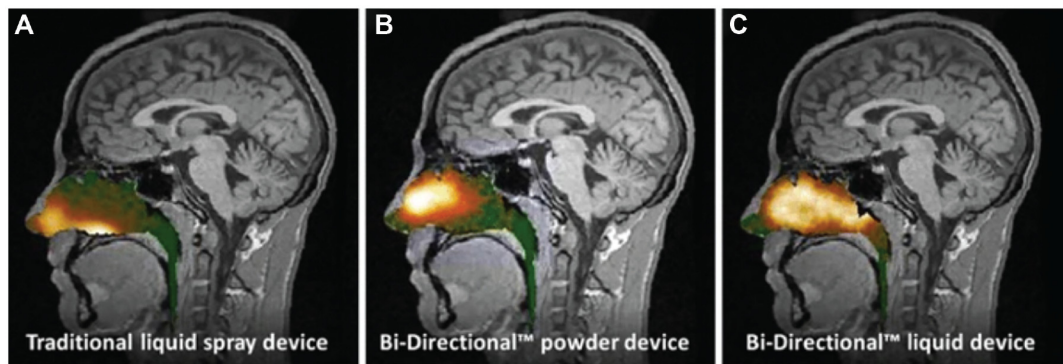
Gamma camera image information from the nasal cavity superimposed on the corresponding sagittal MRI section presenting deposition two minutes after delivery using: (A) a traditional liquid spray, (B) the breath-powered powder device, and (C) the breath-powered liquid spray device incorporating the same spray pump. Reprinted from Djupesland et al (2012).⁸¹
